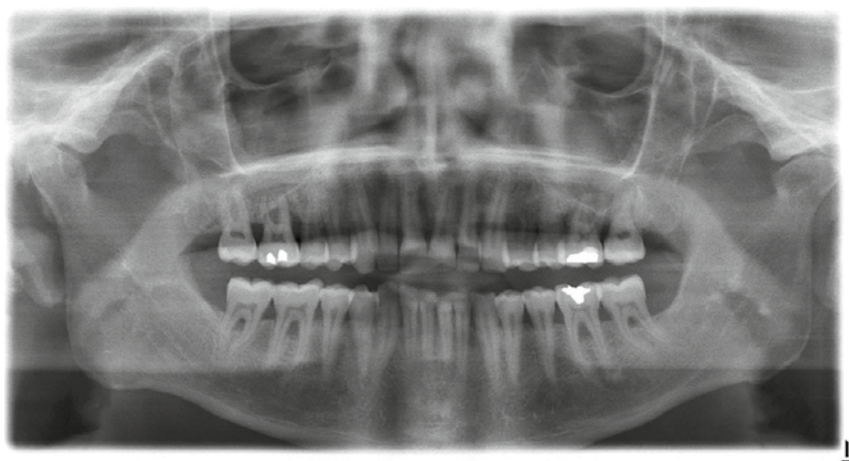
Panoramic radiograph taken six years previously.
